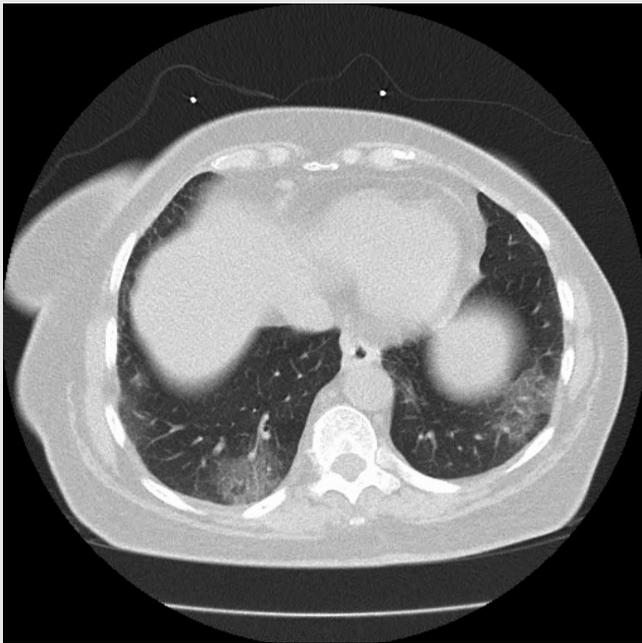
CT images reveal focal ground glass opacities in all lung fields, mostly in the periphery. These are the initial admission images when patient was mildly ill.
